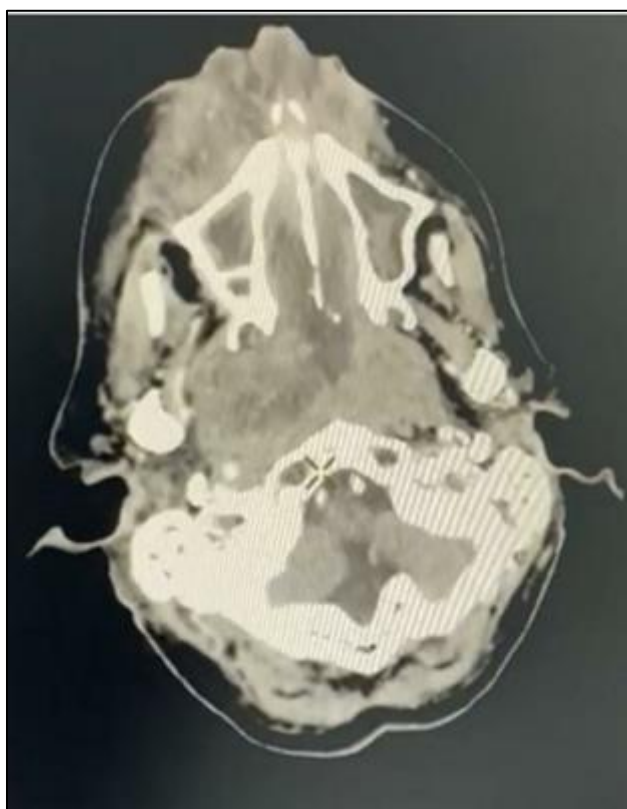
Axial CT scann of the face passing by the nasosinus cavities and nasopharynx
